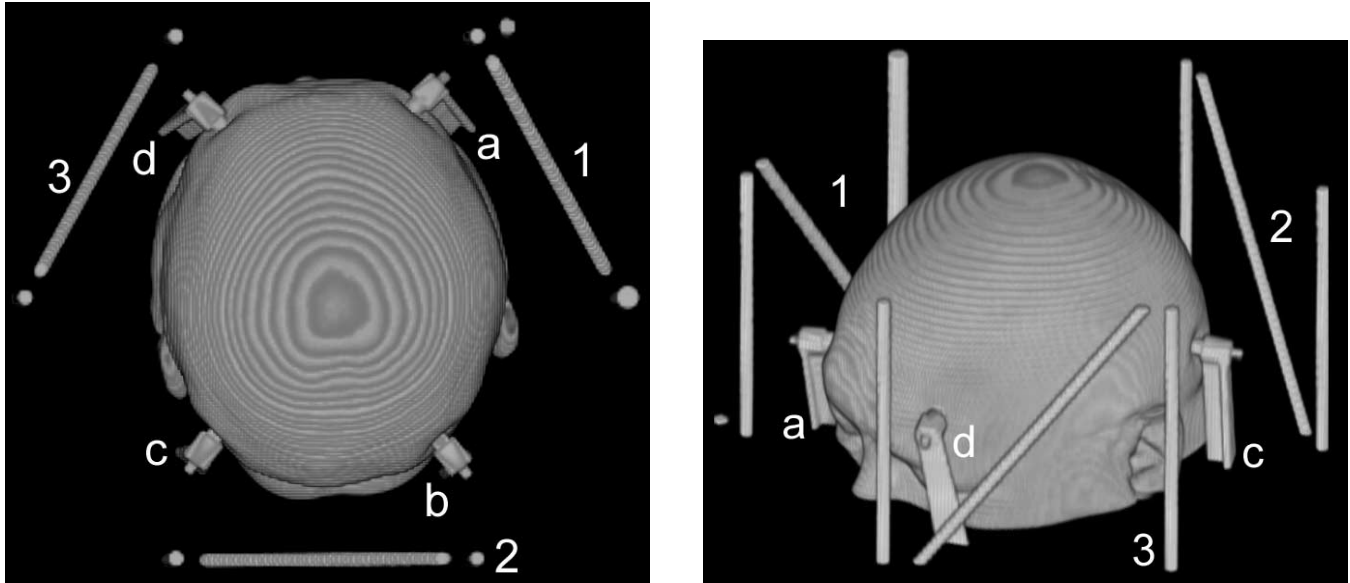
A 3-D volume rendering of a CT image from a patient with an attached stereotactic head frame. *Left:* View from cranial direction, *right:* view from left anterior oblique direction. The stereotactic reference frame or head ring (not visible) is attached to the head by four posts that are labeled “a” through “d”. Registration of the image coordinate system to the physical coordinate space established by the reference frame is accomplished by attaching, just prior to image acquisition, a localizing system consisting of three N-shaped fiducials. These fiducials, often referred to as “N-bars”, each consists of two parallel and one diagonal rod and are labeled “1” through “3”.
